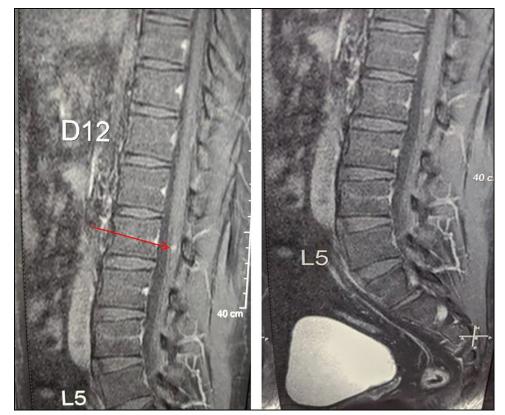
Contract MRI spine depicting a spinal hemangioblastoma at L2 level
